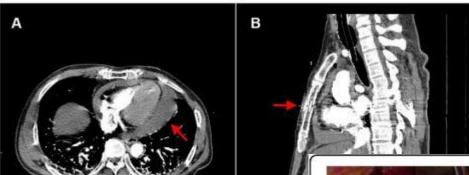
Chest computed tomography at admission. (A) The hemopericardium (re (red arrow) in the saggital view.
